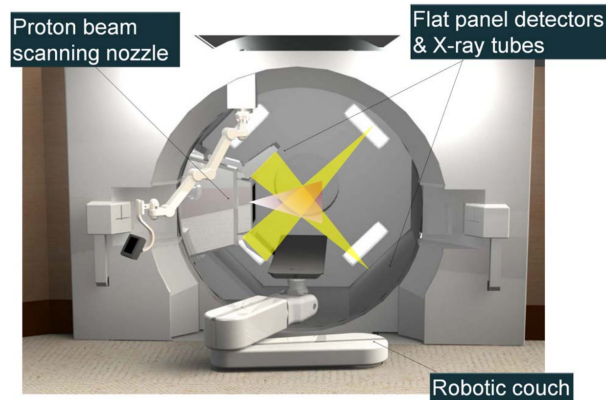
Proton therapy system with integrated X-ray fluoroscopy device developed at Hokkaido University (from Shimizu et al. [12]).
